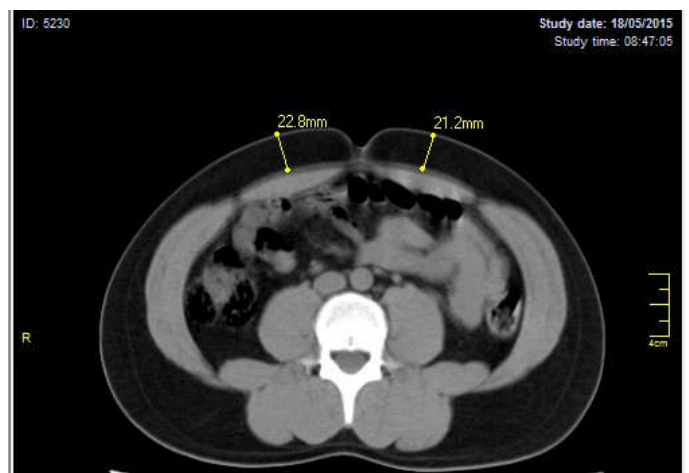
Patient caliper measurement was 4.4 cm, related to 22.8 and 21.2 mm CT scan measurements.
